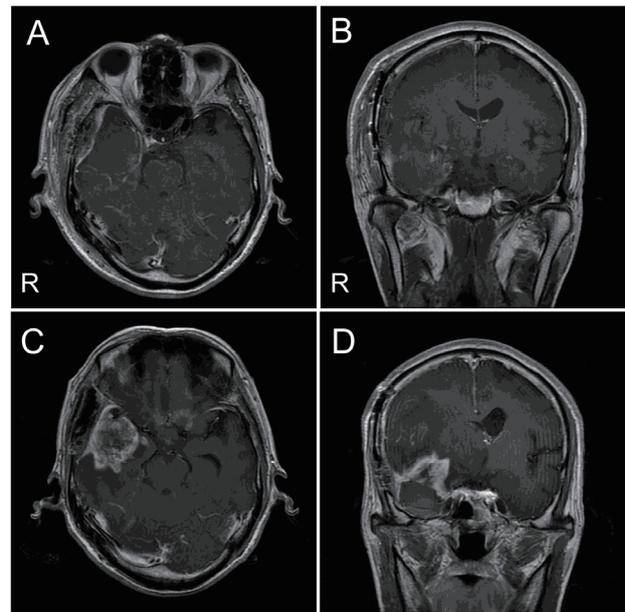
Postoperative (a, b) and follow-up (c, d) magnetic resonance imaging (MRI) on a contrast-enhanced T1WI. Postoperative MRI showing gross total removal of the tumor (a, b). Follow-up MRI obtained 7 months after the surgery showing rim enhancement of the tumor resection cavity, suggesting tumor recurrence (c, d). However, no ventricular wall enhancement or hydrocephalus suggestive of cerebrospinal fluid dissemination was noted.
